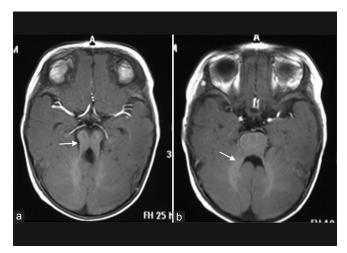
Axial T1-weighted postcontrast image of the brain at the level of midbrain shows prominent thickened and elongated superior cerebellar peduncle giving characteristic "molar tooth appearance" (a, arrow) and "Bat wing" fourth ventricle (b, arrow)
